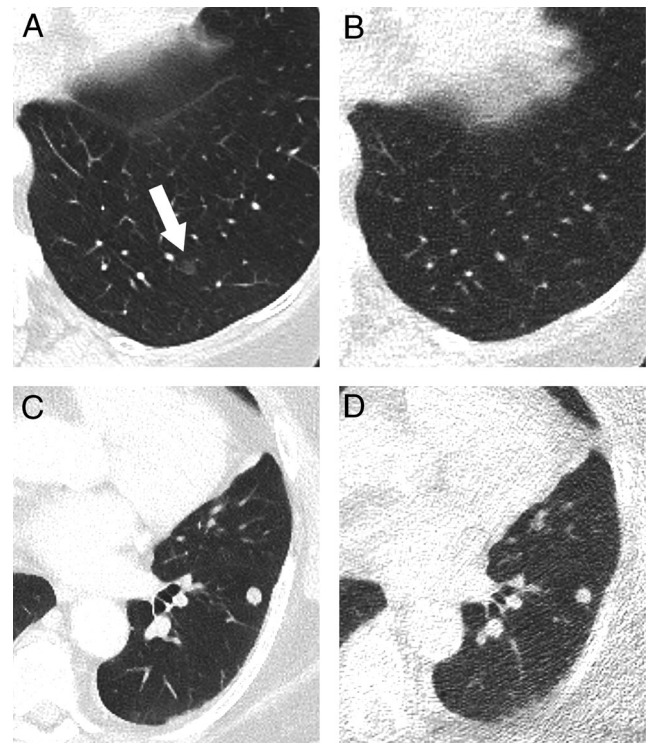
Representative transverse CT sections of the lung in a 75-year-old woman with a body mass index of 24.4 kg/m² scanned with standard dose (A) at 100 kVp and 54 mAs (effective dose, 1.09 mSv; size-specific dose estimate, 3.13 mGy) and ultralow dose (B) at 100 kVp and 70 mAs (effective dose, 0.12 mSv; size-specific dose estimate, 0.34 mGy). The subsolid pulmonary nodule in the left lower lobe (arrow) was not detected by either of the reader in ultralow dose CT (i.e., false negative finding). Representative transverse CT sections of the lung in a 75-year-old woman with a body mass index of 42.8 kg/m² scanned with standard dose (C) at 110 kVp and 142 mAs (effective dose, 4.13 mSv; size-specific dose estimate, 6.86 mGy) and ultralow dose (D) at 100 kVp and 70 mAs (effective dose, 0.13 mSv; size-specific dose estimate, 0.22 mGy). Note the markedly increased image noise in the ultralow dose CT scan. In spite of the image noise the solid pulmonary nodule in the left lower lobe was detected in ultralow dose CT by both readers (i.e., true positive finding)
